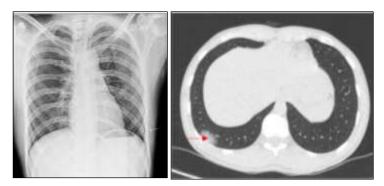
A 23 yr. old, male patient, ~ 4 days of symptom onset, categorized as "no imaging finding-normal" by CXR (PAview) and "mild" with a CT Severity score of 3/25: phenomenon of underestimation of "mild" cases by CXR and superior sensitivity of CT, specially early in the course of disease. One of the GGOs marked by red arrow
